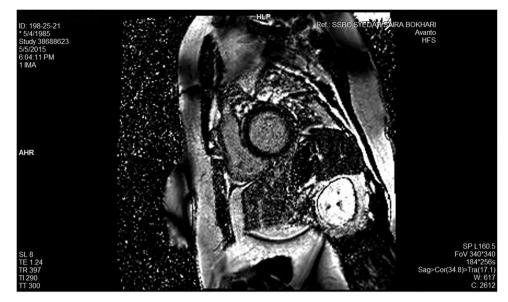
Late cardiac MRI gadolinium image showing midmyocardial enhancement of the basal interventricular septum, suggestive of non-ischaemic cardiomyopathy.
